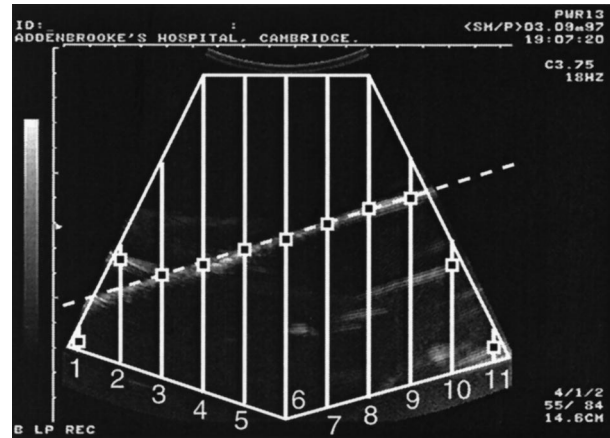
Edge detection and RANSAC line fitting. Vertical lines are sampled within a user-specified region-of-interest in the ultrasound image. For each vertical line, a likely edge point is marked at the location nearest the top of the image where the derivative of the smoothed signal exceeds some threshold. Many, but not all, of these points will lie on the echo from the plane. The line through points 3 and 9 has a consensus set of size 7 because it is consistent with points 3–9. The maximum size of this line's consensus set is 8 because points 1, 10 and 11 could not possibly lie on the line. The line would be accepted if $p < 7/8$.
